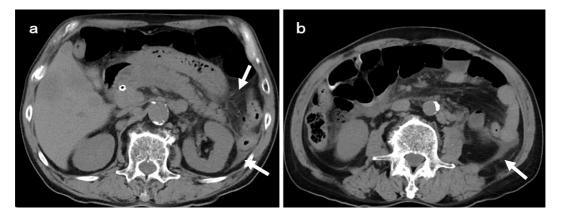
Computed tomography showing severe acute pancreatitis findings. a: The swollen pancreas and spread of inflammation to the abdominal cavity and retroperitoneum (arrows). b: The inflammation spread toward the inferior pole of the left kidney (arrow).
